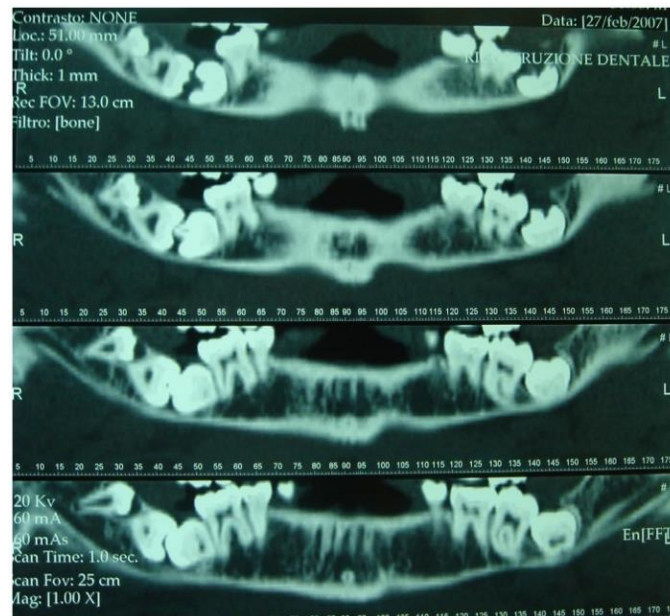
X-Ray of the mandibular arch.*
